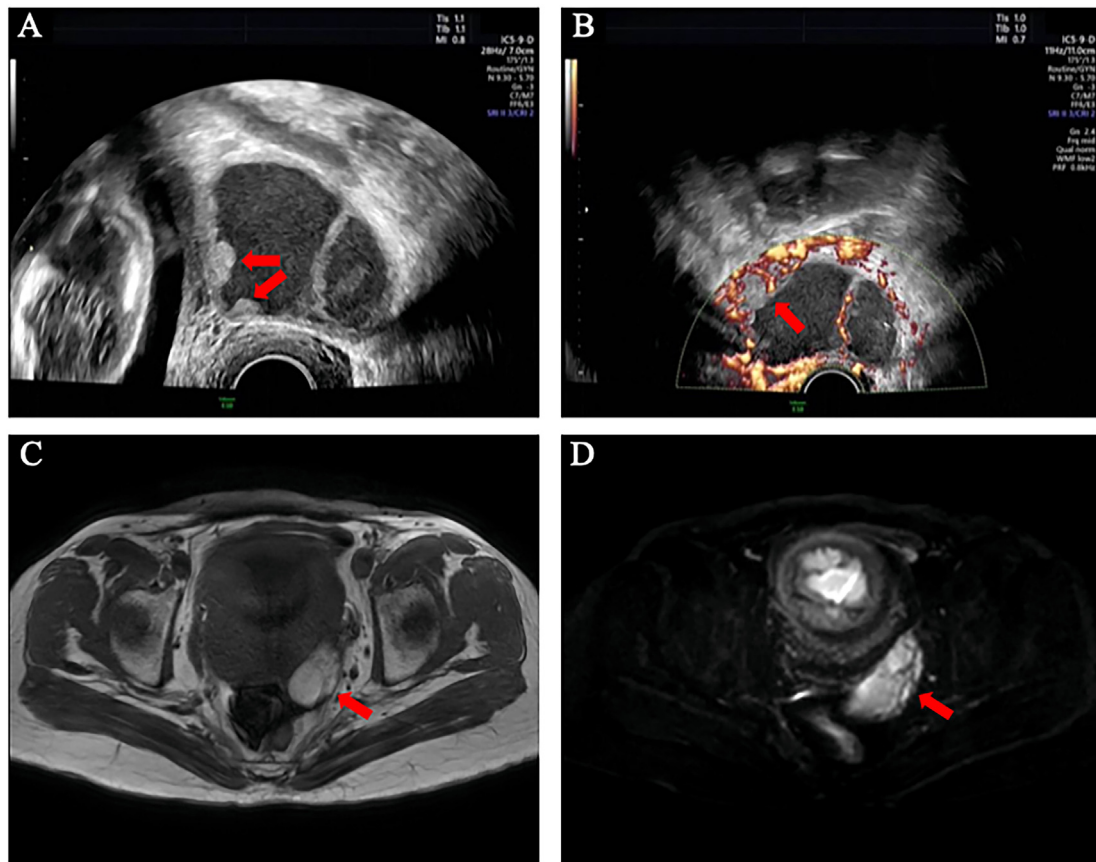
Right ovarian cyst of case 2 at 24⁺⁵ weeks of gestation. A, B. Ultrasound presentation of the cyst. Red arrows indicate the papillae. C. T2-weighted imaging of the cyst. The red arrow indicates the cyst. D. Diffusion-weighted imaging of the cyst. The red arrow indicates the cyst.
